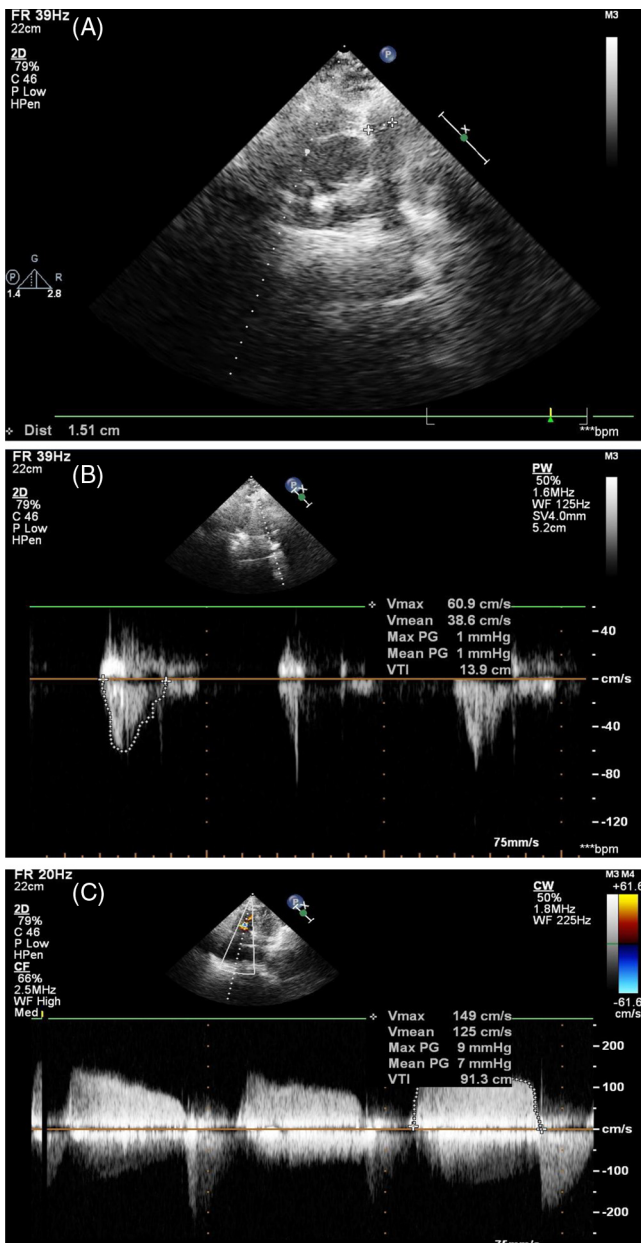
(A) CW Doppler showing mean gradient across the tricuspid valve of 7 mmHg S/O severe T.S., tricuspid valve VTI was 91.0. (B and C) Calculation of stroke volume across RVOT.
